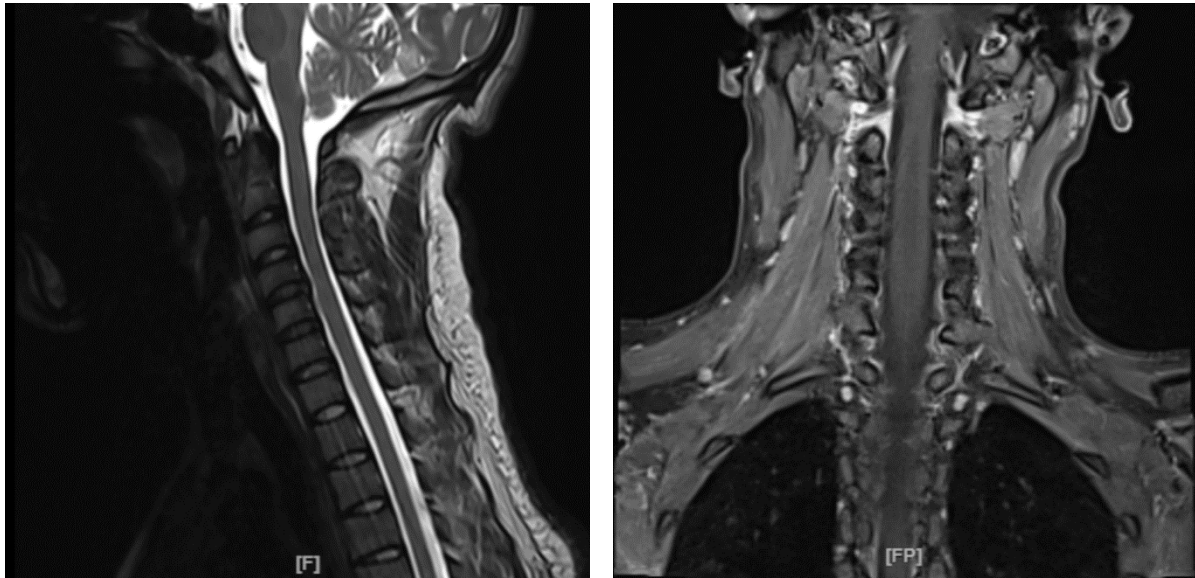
Cervical MRI results
